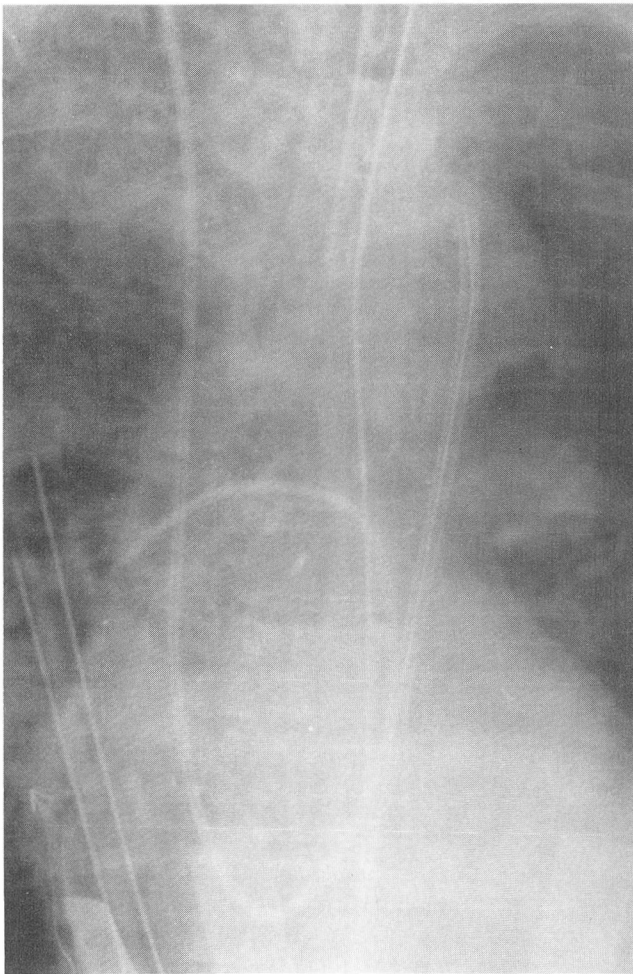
Chest radiograph reveals bilateral homogeneous lung infiltrates. The tip of the Swan-Ganz catheter is located in the right main pulmonary artery.
